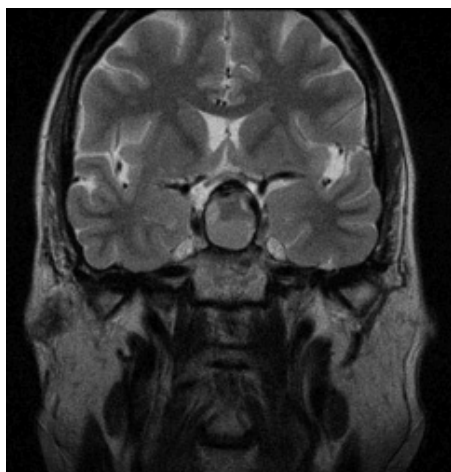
Magnetic resonance imaging of the brain (coronal view).
